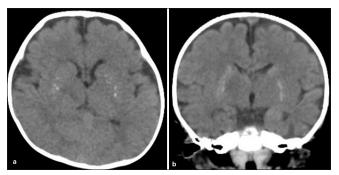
(a and b) Show axial and coronal views of a computed tomography scan of the brain, which shows bilateral curvilinear calcification with hypodensity in the right basal ganglia.
